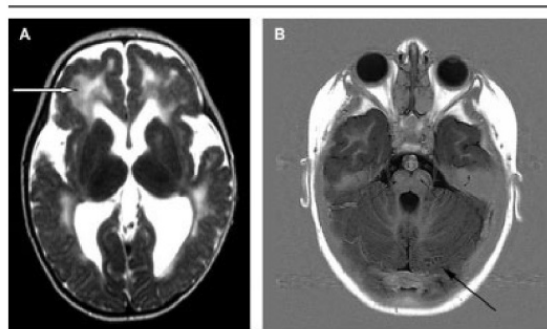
(A) T2-weighted image in the transverse plane of an 8-month-old (Patient 22) with heterozygous *POMGnT1* mutations. There is widespread bilateral polymicrogyria affecting predominantly the frontal and parietal lobes. The white matter is reduced in volume with abnormally high signal intensity. Areas of lower signal intensity, mainly within the anterior white matter (arrow), may represent heterotopic cells or variations in myelination. (B) T1-weighted image in the transverse plane of a 3-year-old (Patient 20) with heterozygous *POMGnT1* mutations. There is a small ventral cleft in the pons. There is an exaggerated rounded appearance to the high signal myelinated corticospinal tracts (thin black arrows). There are several (thick black arrow) cerebellar cysts.
